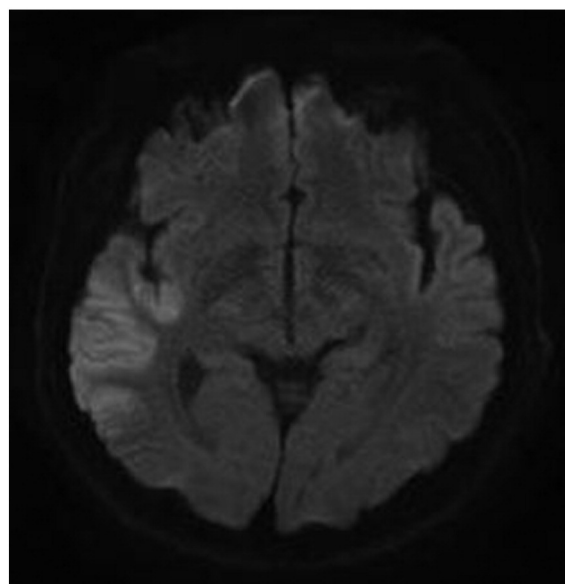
Diffusion-weighted magnetic resonance imaging clearly demonstrated lesions in the right temporal lobe.
